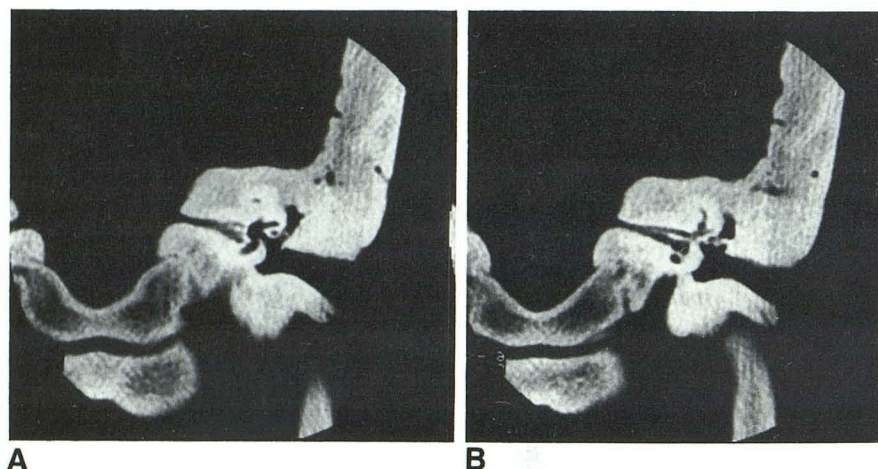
A, Coronal CT scan at internal auditory canal and vestibule. Horizontal portion of postgeniculate portion of the seventh nerve, which is not normally seen, is walled in as shown. Marked narrowing of internal auditory canal and small epitympanum. B, coronal CT scan at level of crista falciformis, which is long and thickened. Facial nerve canal (above) and eighth nerve canal (below). Marked narrowing of internal auditory canal. Ossicles are fused, and incus is fused to lateral wall of epitympanum.
